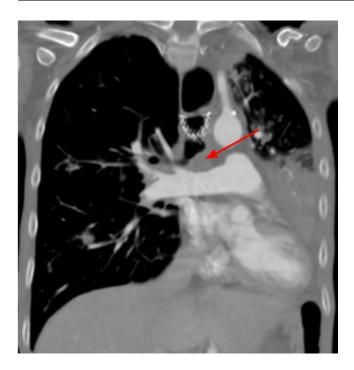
CTA chest coronal view shows obstruction of the proximal left main bronchus and postobstructive consolidative opacities in the ligula. The extrinsic compression from the esophageal stent causing the obstruction is not well seen in this view.
